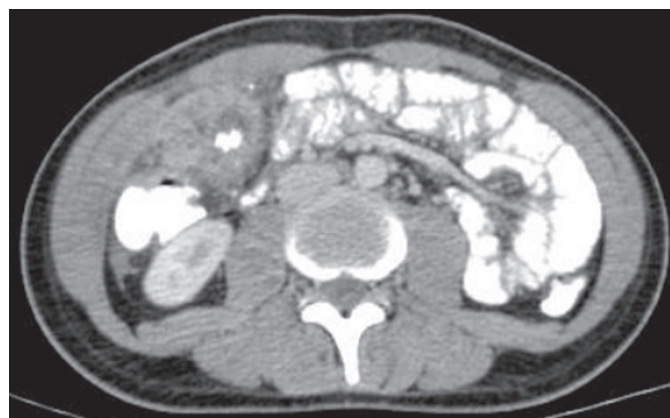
Computed tomography showed that a calcified structure of 2 cm at the right side of the epigastric area had been surrounded by omentum and intestines creating a mass 10 cm.
